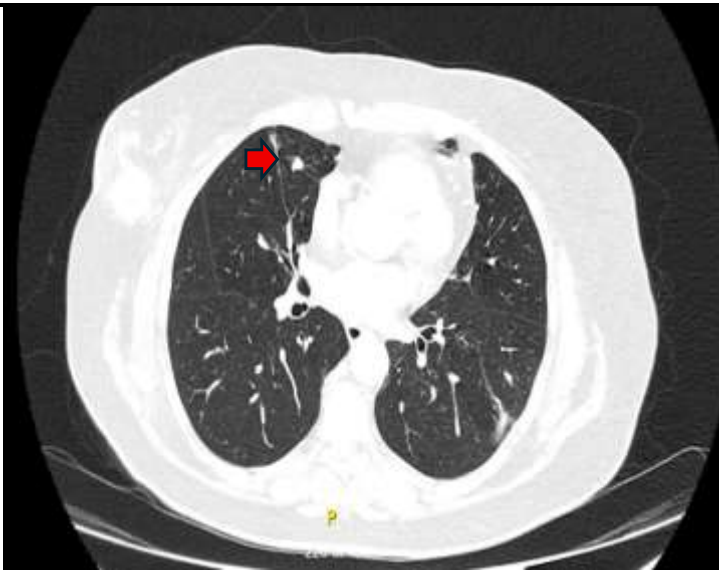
Axial view of CT scan lung window, shows a small pulmonary nodule in the right middle lobe.
